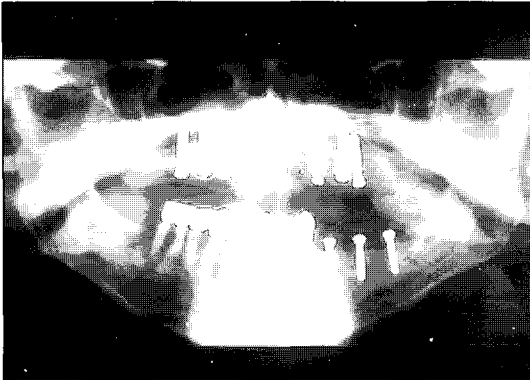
Panoramic radiograph following placement of ITI implants in the maxilla and the mandible.
